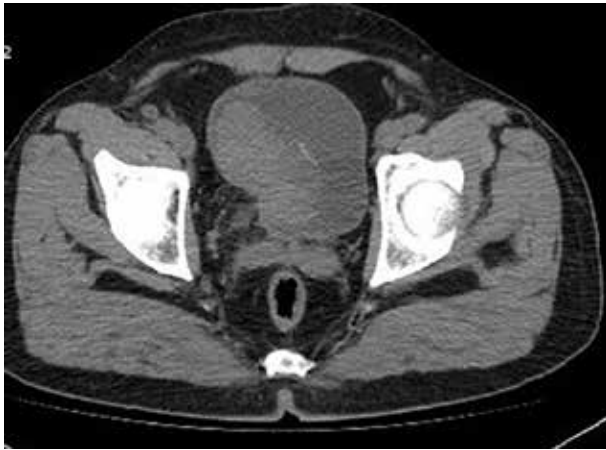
Computed tomography showed 7 x 3 cm polypoid mass at the right bladder wall.
